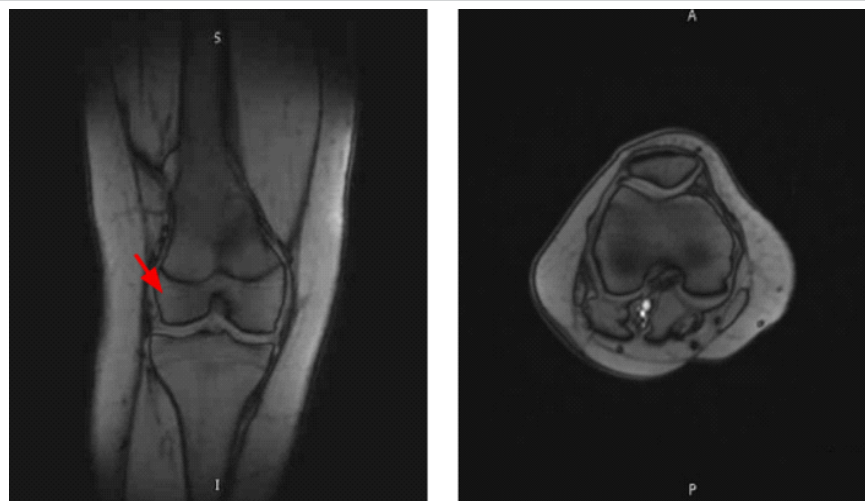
Magnetic resonance imaging of the right knee demonstrated interval disappearance of the previously noted distal femur osteochondroma, with only a small residual cortical projection and no evidence of a cartilaginous cap, soft tissue mass, or abnormal enhancement.
